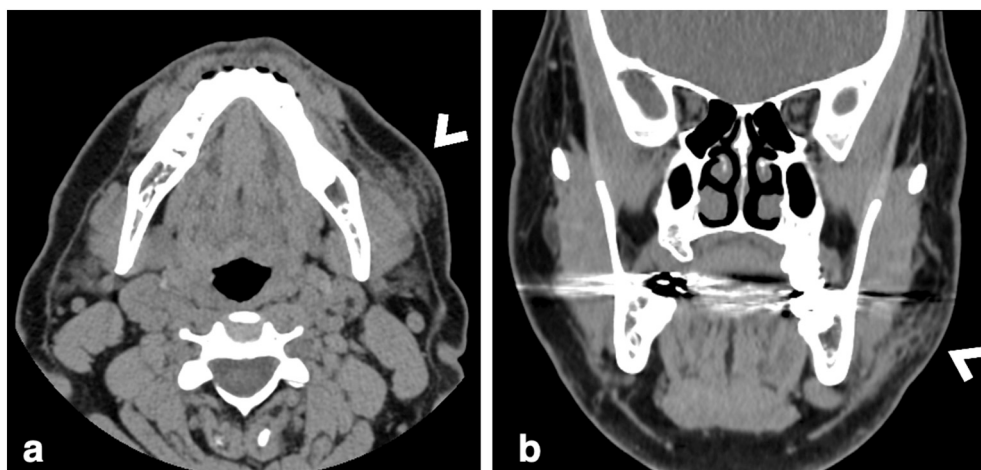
Nonenhanced CT images of the head and neck in axial (a) and coronal (b) reformats revealed a focal area of platysmal thickening and subcutaneous fat stranding by the left angle of the mandible (arrowhead “<”). The remainder of the scan was unremarkable.
